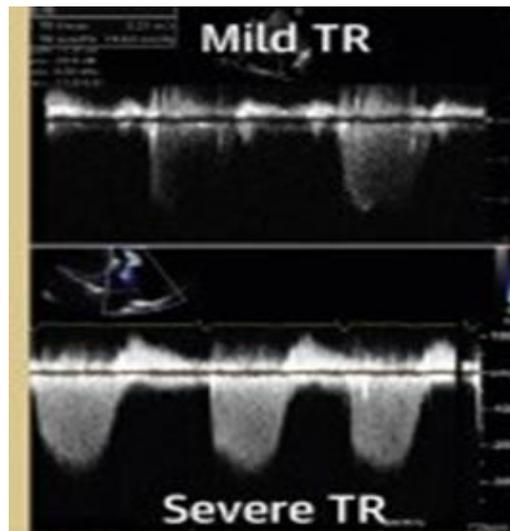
CW doppler of TR (21).
